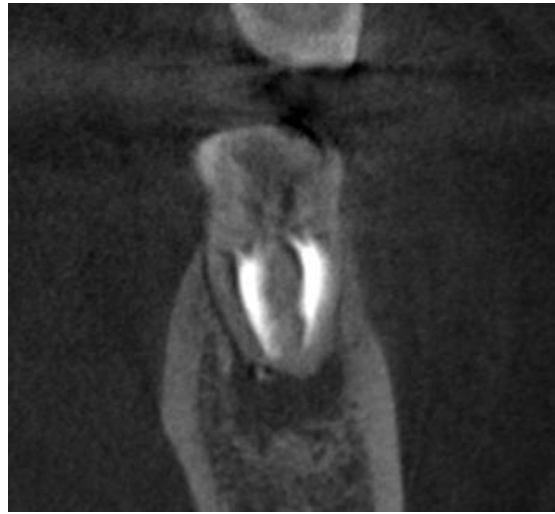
CBCT Coronal View of Mesial Root of #19
